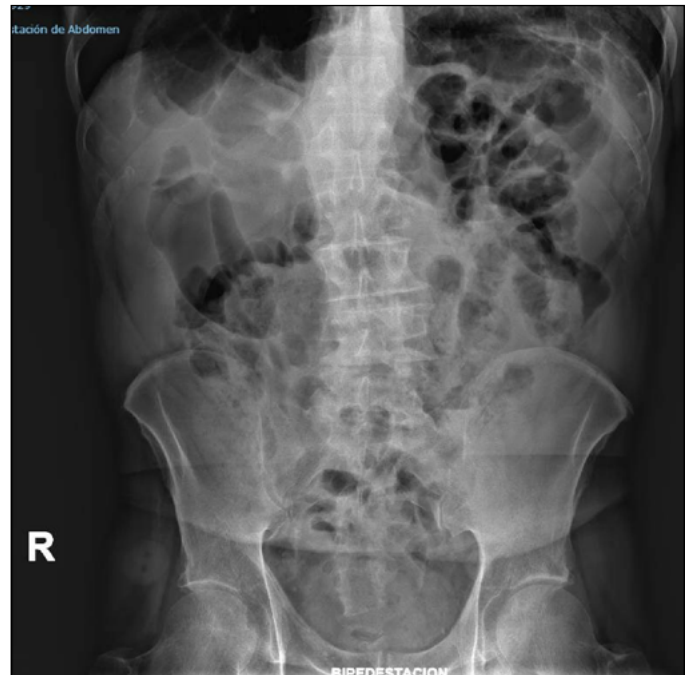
Plain abdominal X-ray in standing position. Performed 48 hours after the endoscopic procedure, showing the absence of rectal fecaloma.
